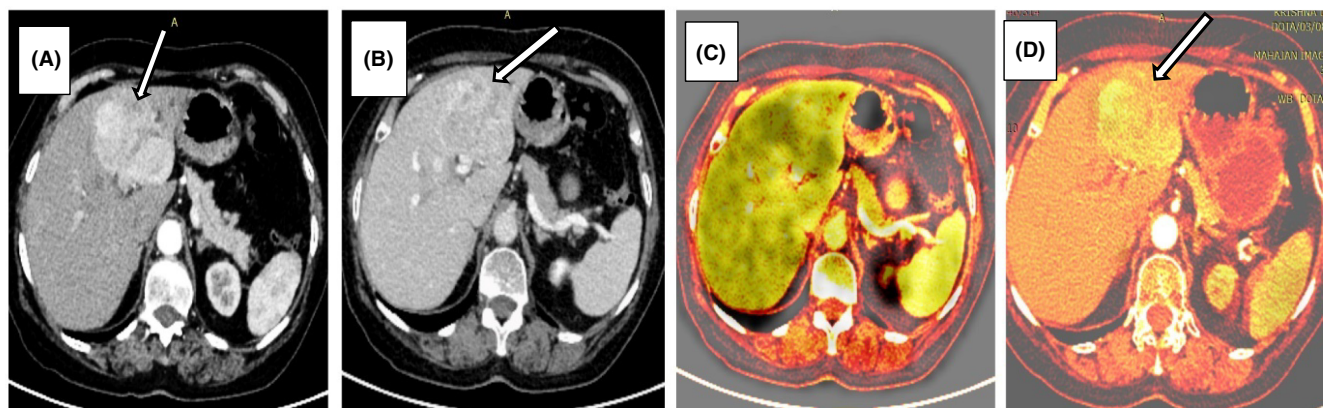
Preoperative images. (A, B) Triple phase CECT abdomen revealed a $5.8 \times 6 \times 6.2$ cm heterogeneous hypodense lesion involving segments IVa and IVb of liver (white arrow) with nodular enhancement on arterial phase, early washout in venous and delayed phases. (C) 18-FDG PET-CT did not reveal any focus of increased FDG uptake. (D) DOTANOC PET CT showed a SSTR-expressing lesion in left lobe of liver (white arrow) with no disease elsewhere.
